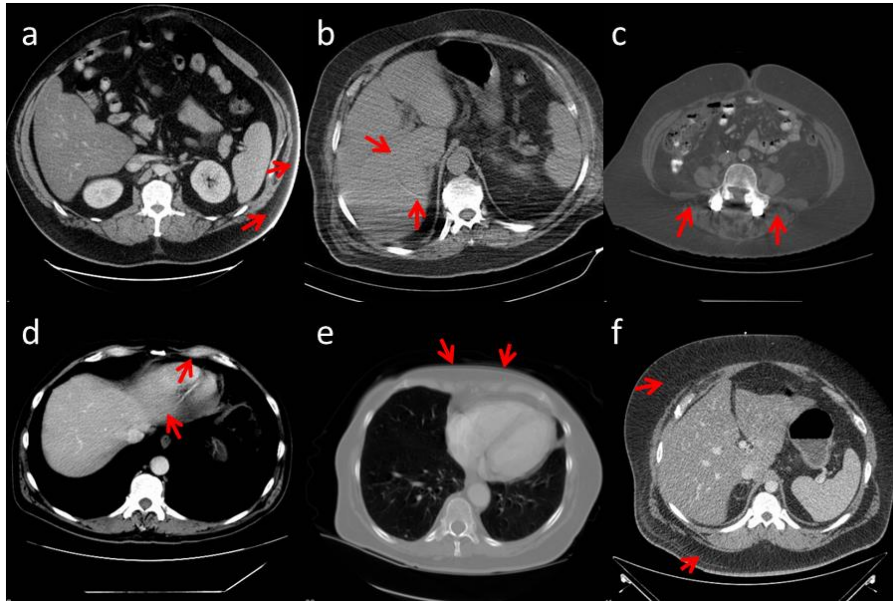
Common CT artifacts: (a) streak artifact caused by body-scanner contact; (b) ring artifact; (c) windmill streak; (d) partial volume effect; (e) motion artifact; (f) streak artifact
